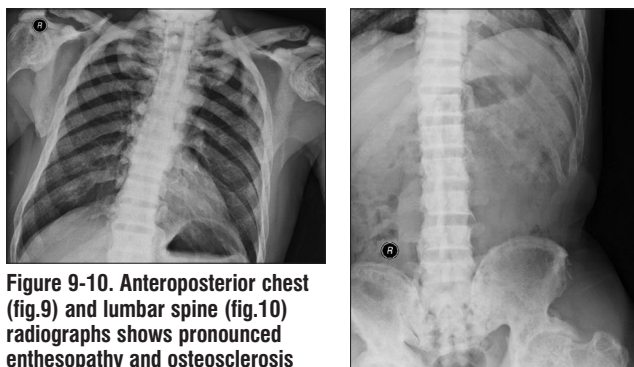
Anteroposterior chest (fig.9) and lumbar spine (fig.10) radiographs shows pronounced enthesopathy and osteosclerosis
